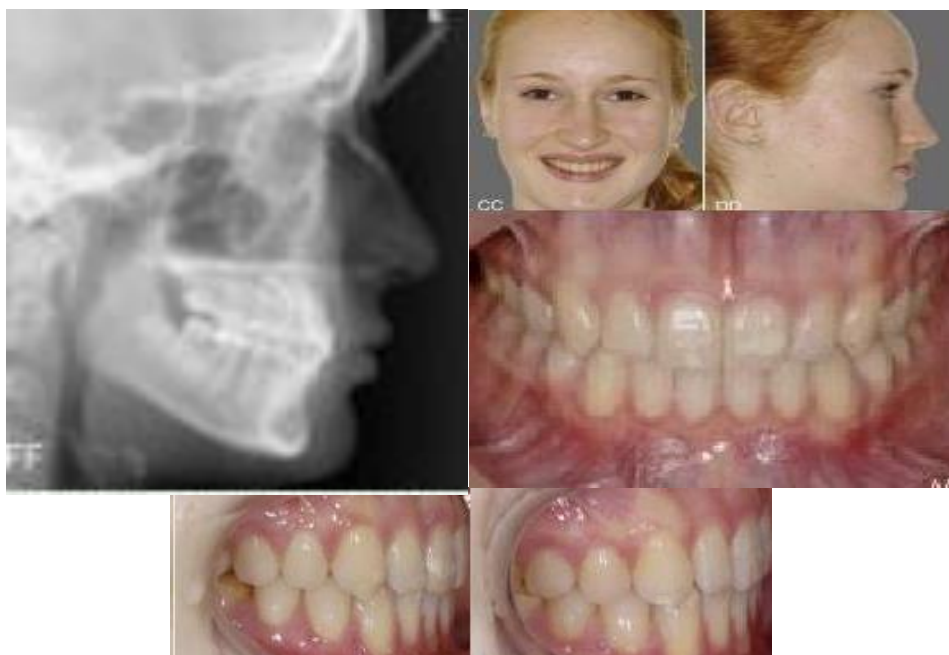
Post treatment radiograph, facial and intraoral photographs (Roberts and Huja, 2016)
